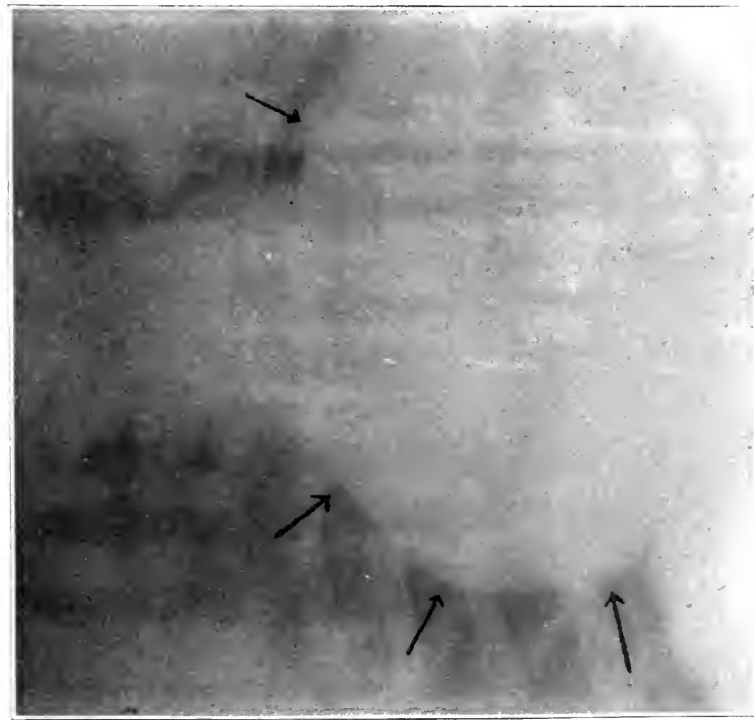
Roentgenogram of patient suffering from aneurysm involving the sinus of Valsalva which ruptured within the pericardium, filling the sac. Typical water bottle shape of shadow. Blood aspirated from pericardium. Diagnosis made antemortem.
